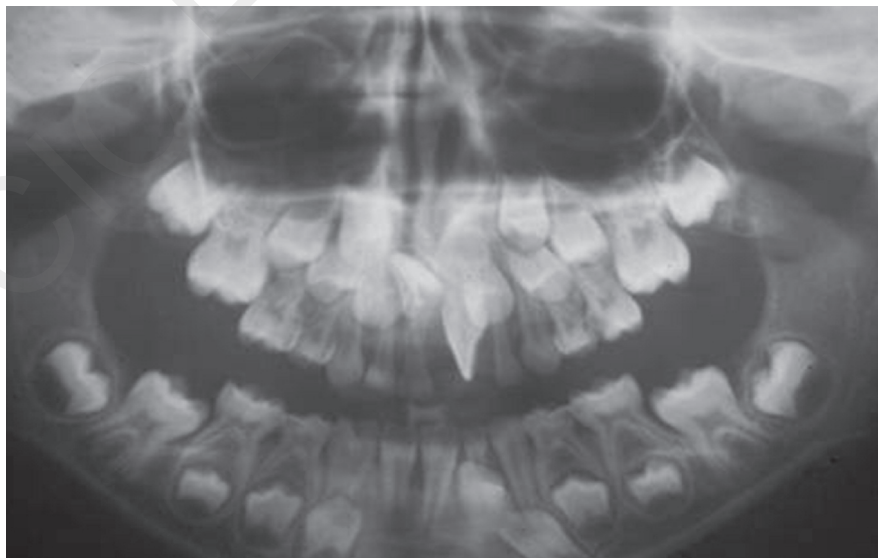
Panoramic radiograph showing in the right side of the maxilla the deciduous incisors and the inclusion of the permanent central incisor and in the left side the rotated permanent left central incisor and the lateral primary incisor.
